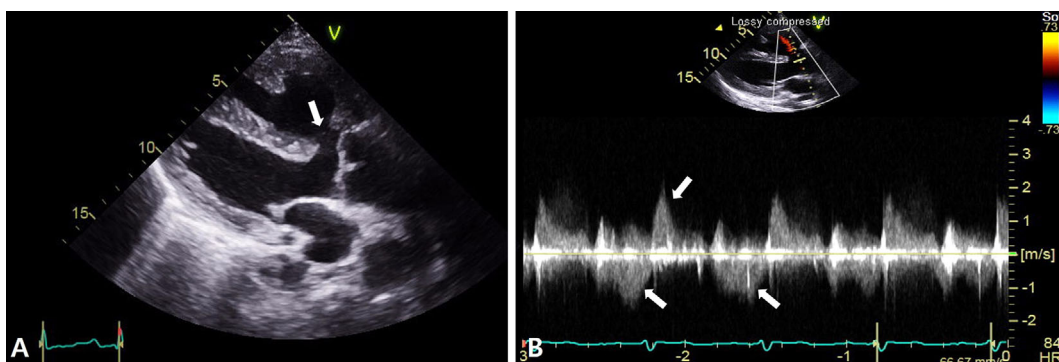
Transthoracic echocardiography. Muscular-type ventricular septal defect (A) with a bi-directional flow (B).
